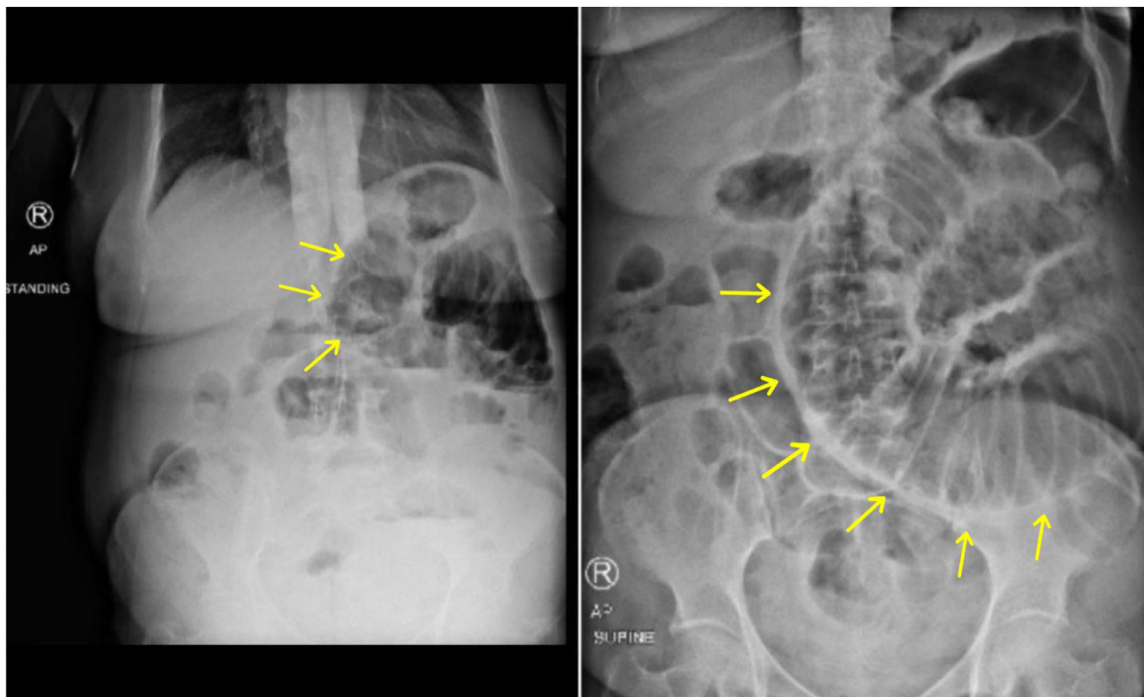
X-ray images, indicated by Yellow Arrows, demonstrate multiple air-fluid levels within the small bowel, which are indicative of a small bowel obstruction.
